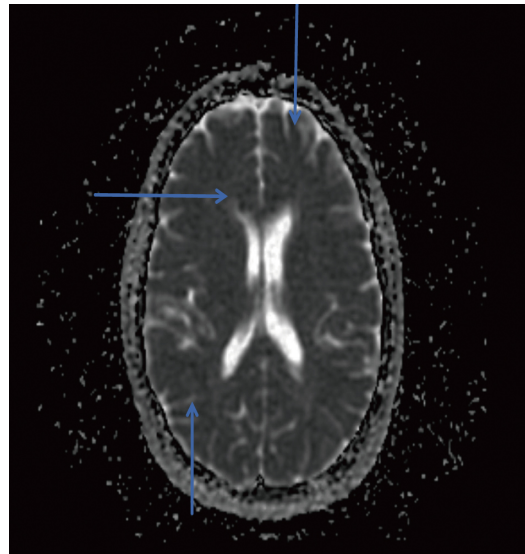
MRI-ADC sequence of asymptomatic cerebral infarction. Blue arrows indicate regions of restricted diffusion associated with silent cerebral infarction, as identified on ADC mapping. MRI, Magnetic Resonance Imaging; ADC, Apparent Diffusion Coefficient.
